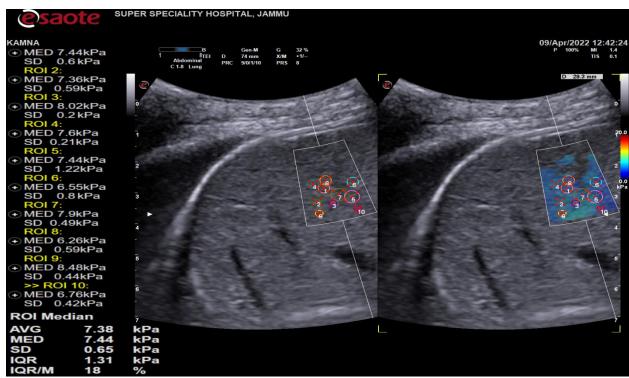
Ultrasound examination of a liver with mild steatosis, as characterized by the slightly increased echogenicity of the liver parenchyma. 2D-SWE study showing stiffness of 7.3kPa, consistent with a METAVIR stage of F2. The elastography map is homogeneous and predominantly blue, indicating less stiffness
